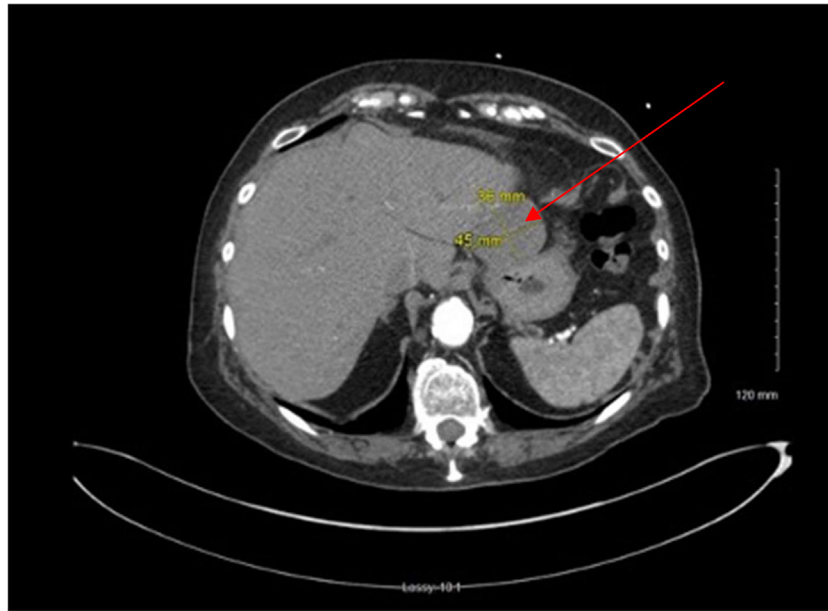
CTA demonstrating mass (red arrow) between the liver and stomach.
